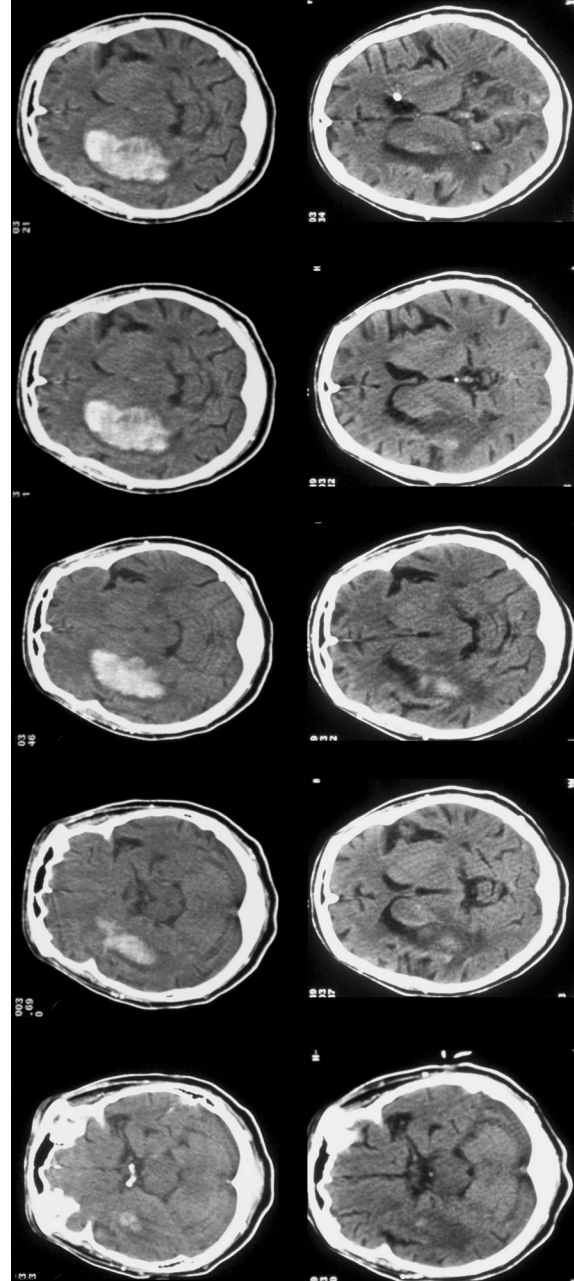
(Top) Admission head CT scan in a patient with a right basal ganglia hypertensive ICH (patient 5). (Bottom) Head CT scan 13 days later, after clot aspiration and thrombolysis, demonstrating near-complete clot resolution.
